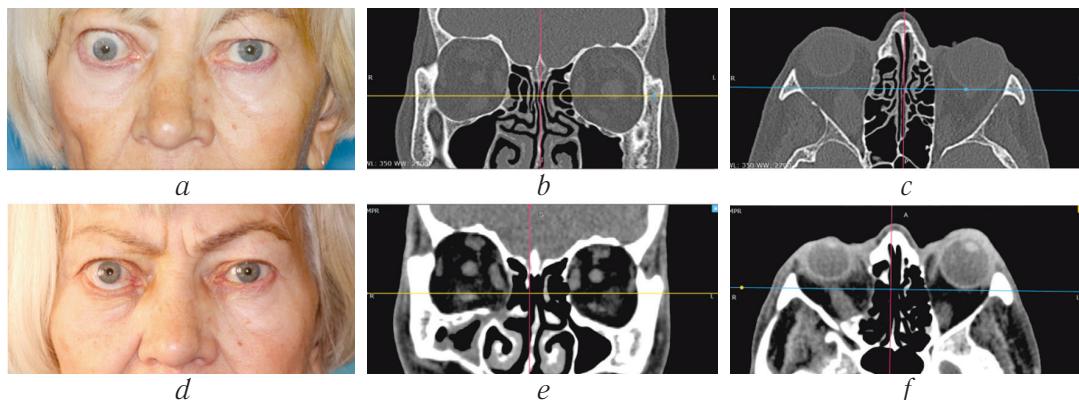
The patient's appearance (*a*) and CT scan before surgery: *b* – frontal plane, *c* – axial plane; and 6 months after right side endoscopic endonasal orbital decompression: *d* – appearance; *e* – frontal plane; *f* – axial plane
